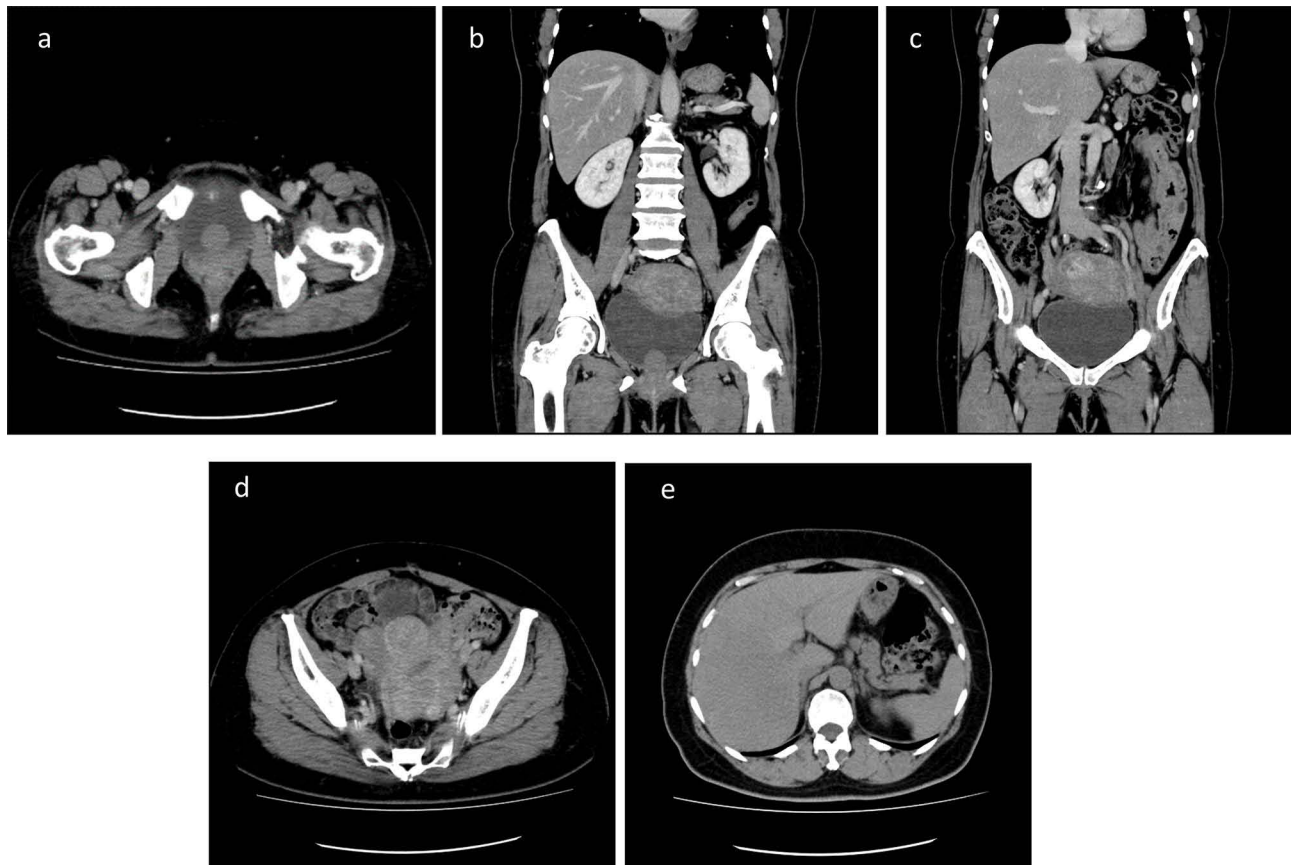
CT images. Contrast-enhanced CT shows axial (a) and coronal (b) views of a smooth-surfaced mass in the urinary bladder. Contrast-enhanced CT shows axial (c) and coronal (d) views of multiple uterine fibroids. (e) CT axial view of a fatty liver.
